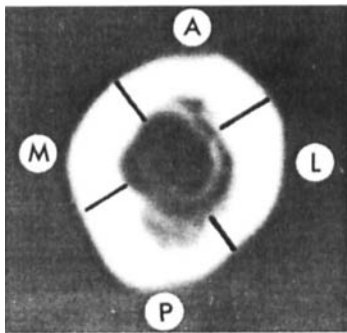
CT scan of the previously nailed femur. The lines indicate the four quadrants (A anterior, M medial, P posterior, L lateral) where cortical thickness and density were measured.
